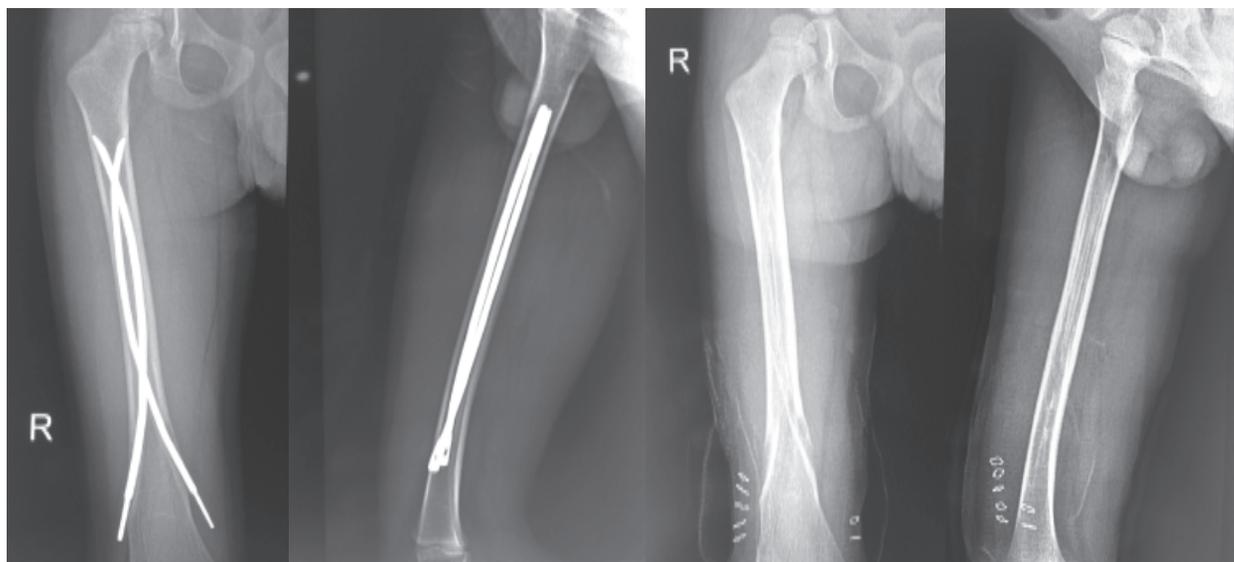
Old fracture well united with Ender’s nails in situ, Figure 3c & 3d: X-rays after implant removal
